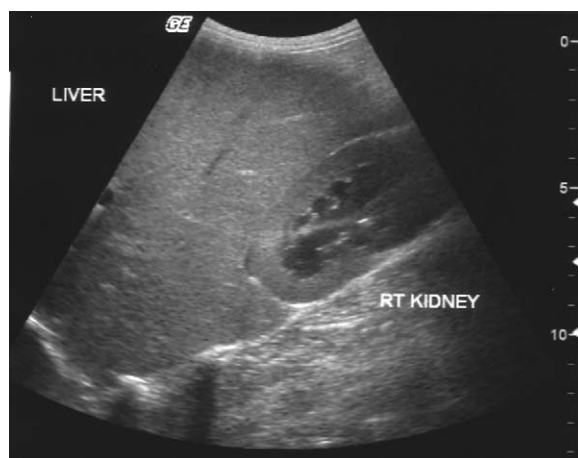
Ultrasonographic image demonstrating bright hepatic parenchyma and hepatomegaly as evidenced by liver contacting dorsal and lateral surfaces of the right kidney.
